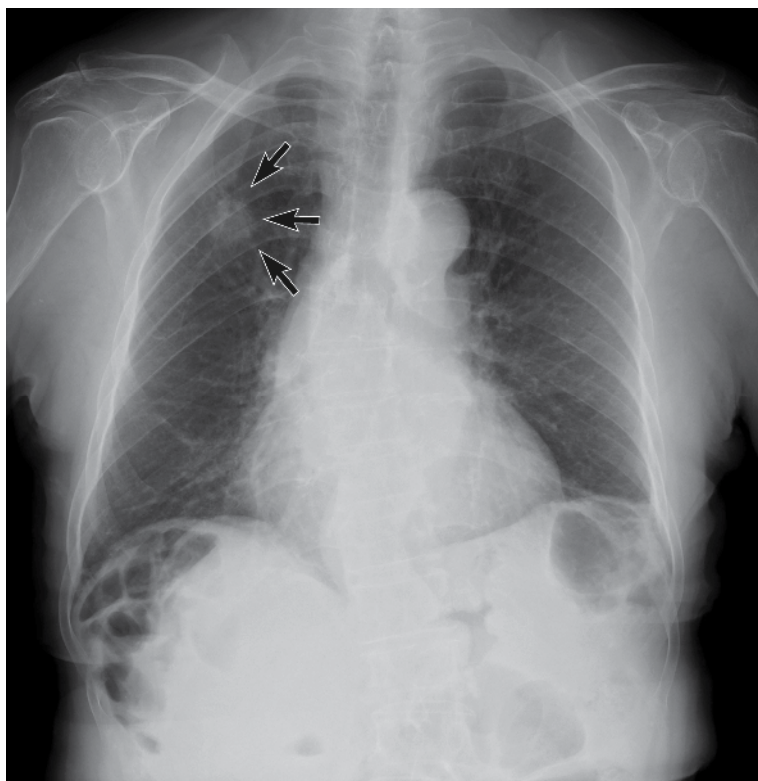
A chest radiography demonstrates a spiculated mass of approximately 2cm in diameter, in the right upper field of the lung.
